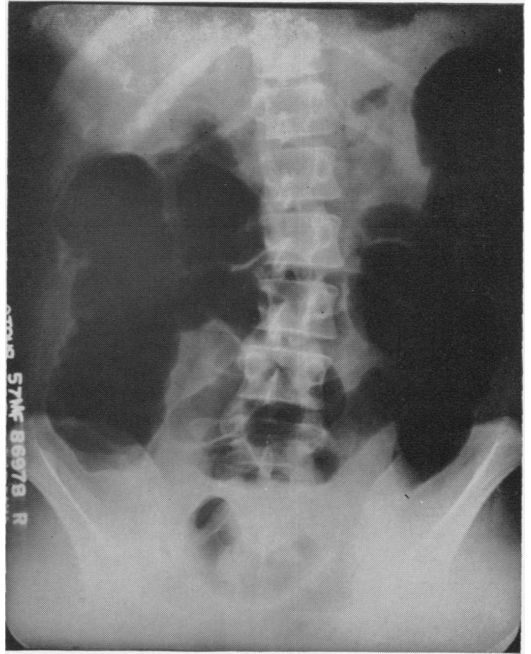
Preoperative plain film in Case 3.
